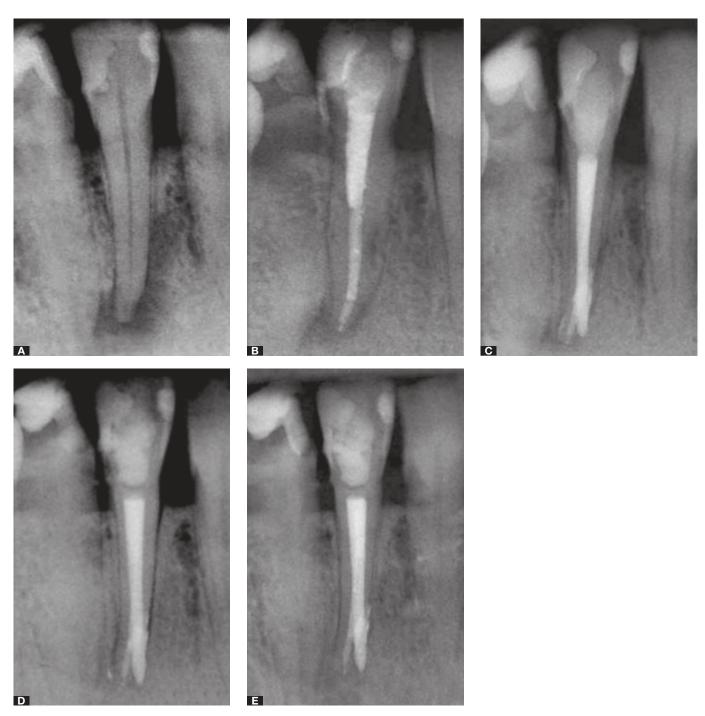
A) Initial radiograph; B) Final radiograph; C) Final radiograph showing deviation and perforation; D) 3-year follow-up; E) 5-year follow-up.
